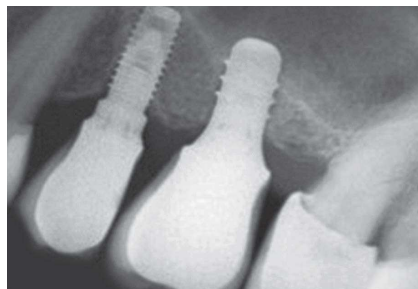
Radiographic image after restoration placement.
